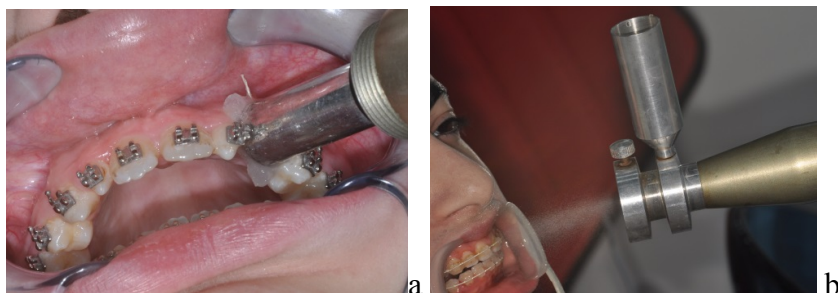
Low-frequency ultrasound devices:
